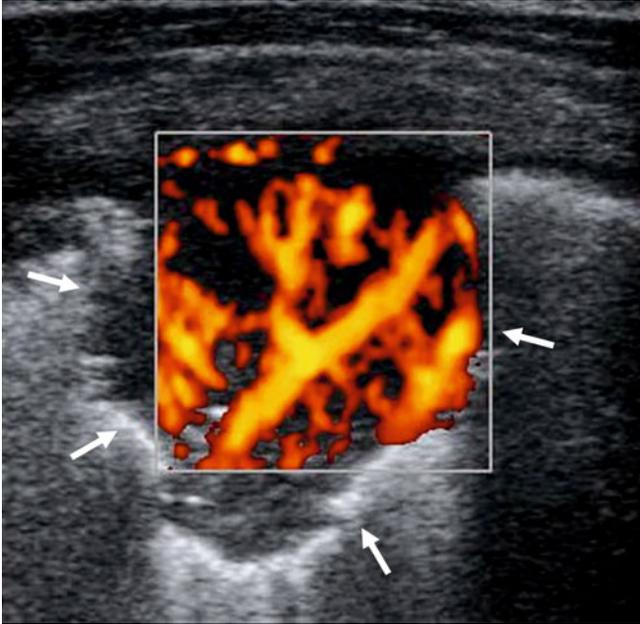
Pneumonia. Ultrasound findings. Ultrasound image shows a hypoechoic area (*arrows*) representing an area of lung consolidation with increased vascular flow. No anomalous vessel to suggest sequestration
